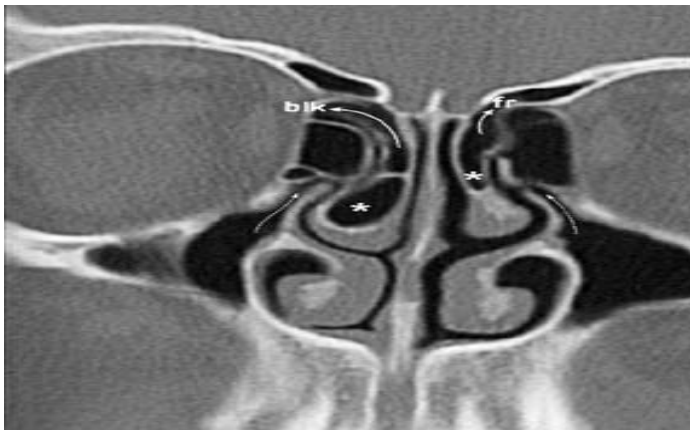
On the coronal CT image, the ostium of extensive type concha bullosa (asterisk) on both sides drain into the frontal recesses (fr) and both recesses are open (dashed arrows).
